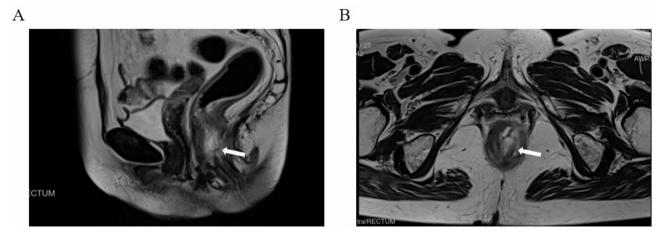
A, B. MRI examination of the patient. The tumor (arrow) presented as a circular wall thickening that is located in the lower rectum below the level of the anterior peritoneal reflection
